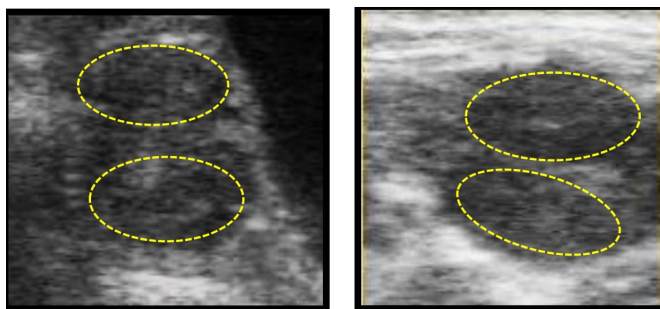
Ultrasound picture of newly formed CLs after ovulation in Letrozole treated ewes during early luteinization
